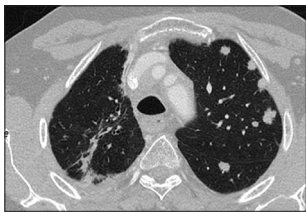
Computed tomography scan before immunotherapy
